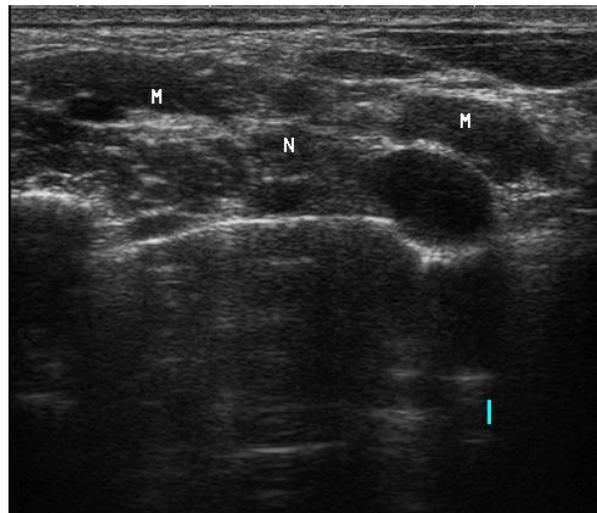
Examination of the supraclavicular region. Linear probe placed longitudinally on the lateral base of the neck (a). Corresponding sonographic image (b). Brachial plexus (N); Scalene muscles (M).
